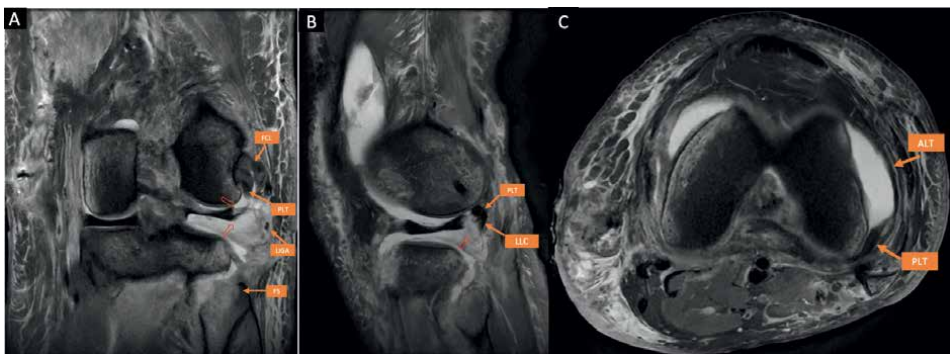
MR images of a 23-year-old man with left knee PLC injury caused in a motorcycle accident. (A) Coronal proton-density weighted fat-saturated T2 sequence with popliteomeniscal fascicles disruption (red open arrow) and complete tear of fibular collateral ligament (FCL) and popliteus tendon (PLT). Lateral inferior genicular artery (LIGA), fibular styloid (FS). (B) Sagittal proton-density weighted fat-saturated T2 image with PLT tear and disruption of posterolateral ligamento-capsule complex (LCC) and evident disruption of popliteomeniscal fascicles (red open arrow). (C) Axial proton-density weighted fat-saturated T2 sequence with posterolateral capsule injury, midthird lateral capsular ligament (ALT).
